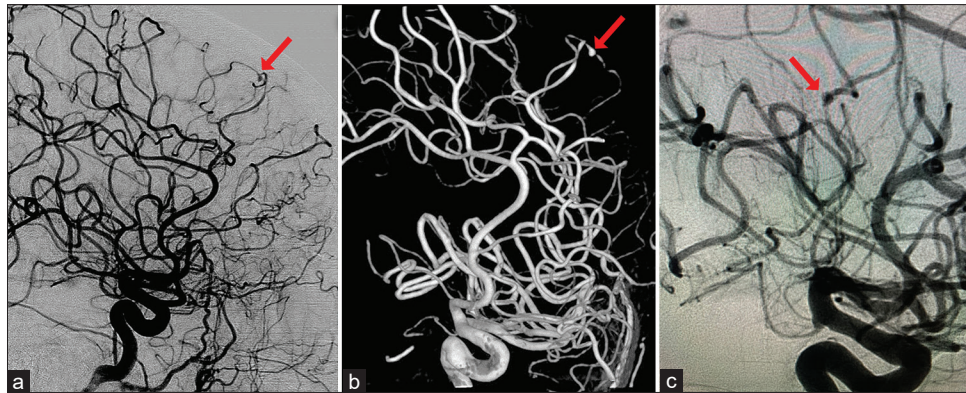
Follow-up radiographic imaging. (a) Digital subtraction angiography (DSA) of a new pseudoaneurysm arising from a distal branch of the left callosomarginal artery (red arrow), (b) 3D DSA of the aneurysm (red arrow), (c) DSA of small pseudoaneurysm arising from a distal M2 anterior division branch of the right middle cerebral artery (red arrow).
